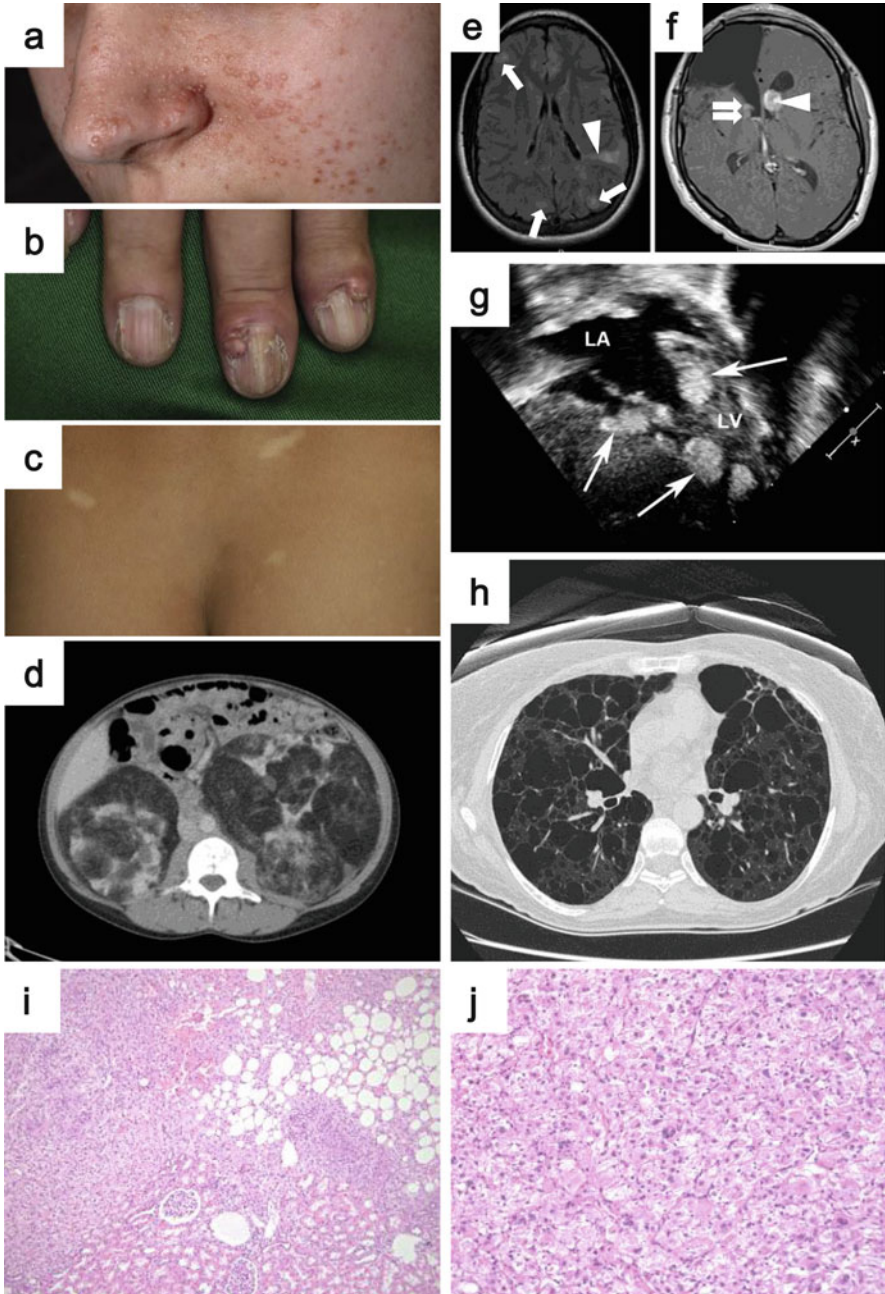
Clinical manifestations of TSC. (a) Angiofibromas on the centropal area. (b) Ungual fibromas arising from the nail bed. (c) Hypomelanotic macules are observed frequently in TSC patients. (d) CT image showing bilateral multifocal angiomyolipomas. (e) MRI image demonstrating cortical dysplasia, which is observed very frequently in TSC patients (*arrows*: tubers, *arrowhead*: radial migration line). (f) MRI image indicating subependymal nodules (SEN) with *arrows* and subependymal
